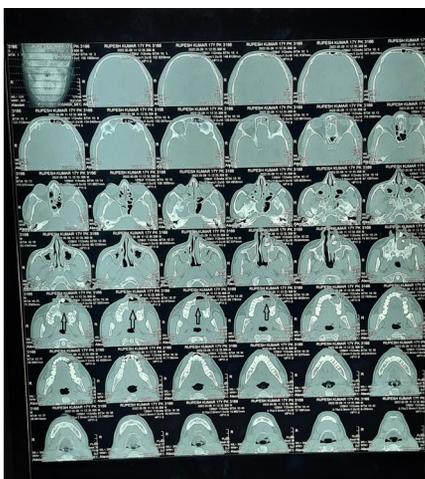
Axial CT scan finding showed an osteolytic heterogeneous cystic lesion occupying the left anterolateral maxilla of size (5cm x6cm) appx. with expansion of buccal and palatal cortical plate
